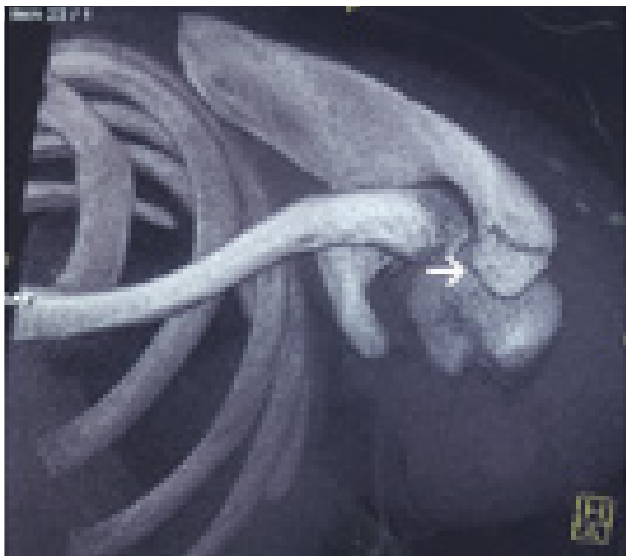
Coronal volume-rendered 3-dimensional computed tomography image reconstructed in axial oblique projection shows the os acromiale (arrow) to best advantage. However, bone-marrow edema, clearly visible on magnetic resonance imaging, is not identifiable with computed tomography.
